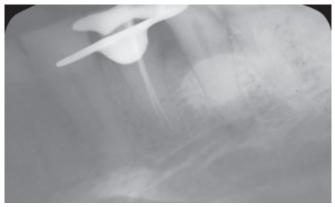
Master cone radiograph (Case 1)
